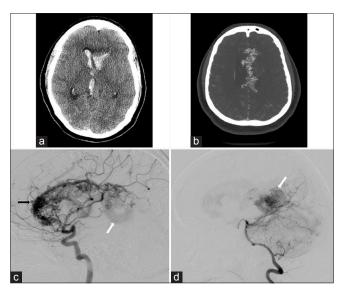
(a) Axial noncontrast computed tomography scan obtained on a young female patient presenting to our institution with headaches and altered mental status shows intraventricular hemorrhage. (b) Axial computed tomography angiogram performed on the same patient reveals an extensive arteriovenous malformation involving the entire corpus callosum (holocallosal). (c) Lateral projection of internal carotid artery injection reveals a large arteriovenous malformation involving the genu, rostrum, and body of the corpus callosum. Intranidal aneurysm is also appreciated (black arrow). Early venous drainage is seen via galenic system (white arrow). (d) Lateral projection of vertebral artery injection reveals filling of the splenial component of the arteriovenous malformation nidus not seen with internal carotid artery injection (white arrow)
